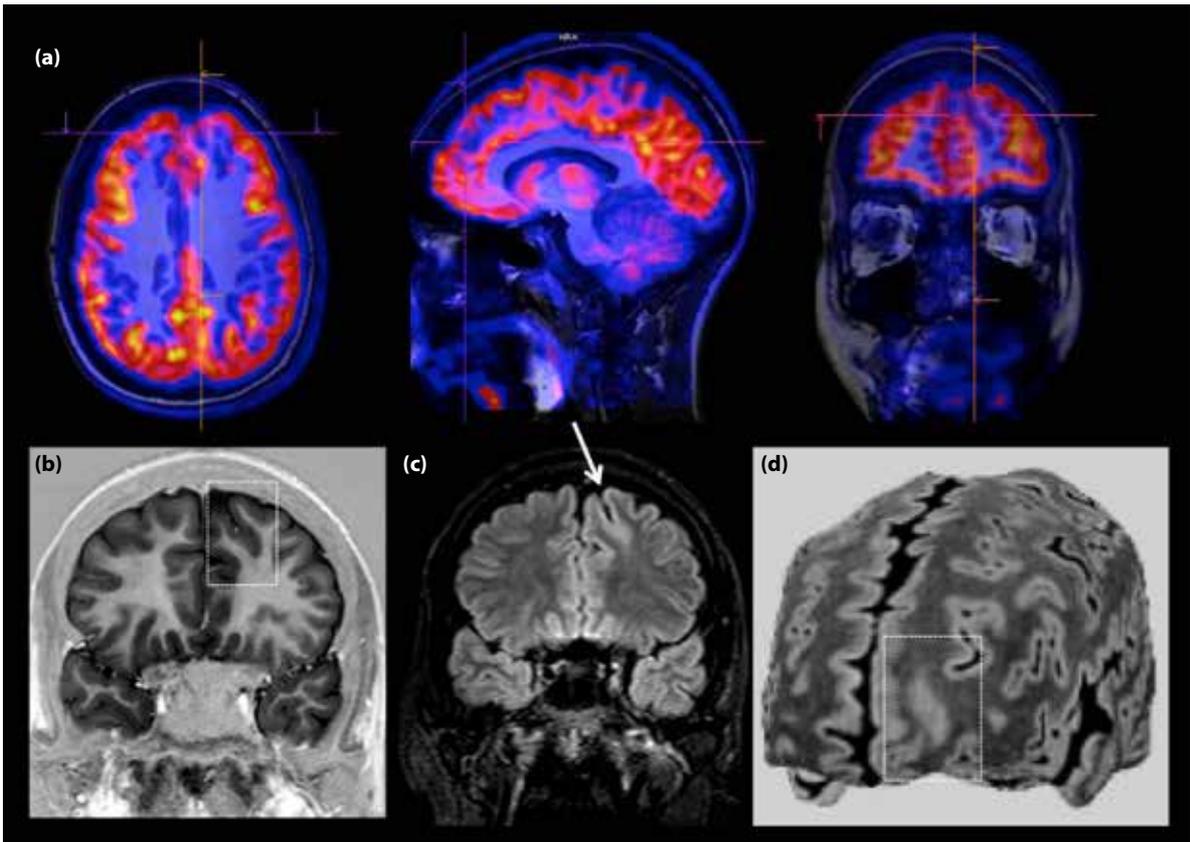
Deep bottom sulcus dysplasia. (a) FDG-PET showing left frontal lobe hypometabolism. (b, c) T1WI and FLAIR MRI sequences coronal slices show cortical thickness in the left superior frontal sulcus with hyperintensity of white matter. (d) Curvilinear reconstruction shows similar findings and extension of these lesions, allowing surgery planning.
